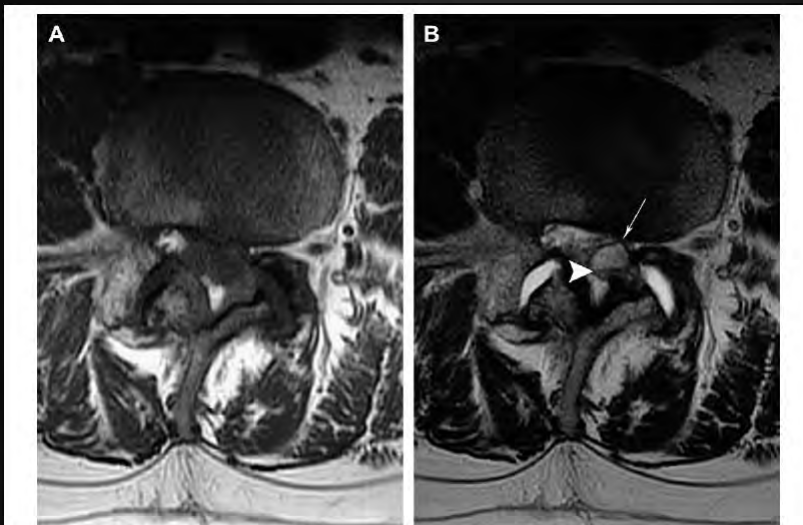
Hemorrhagic synovial cyst. A 56-year-old man presents with acute left leg and back pain. Axial T1-weighted (A) MR image demonstrates bilateral L4-L5 facet osteoarthritis, but the synovial cyst is difficult to identify because it is isointense to cerebrospinal fluid. Axial T2-weighted MR image (B) clearly shows bilateral joint effusions and a well-defined synovial cyst (white arrow), with a fluid-blood level (arrowhead) arising from the left-sided joint and low-intensity fibrotic rim.
